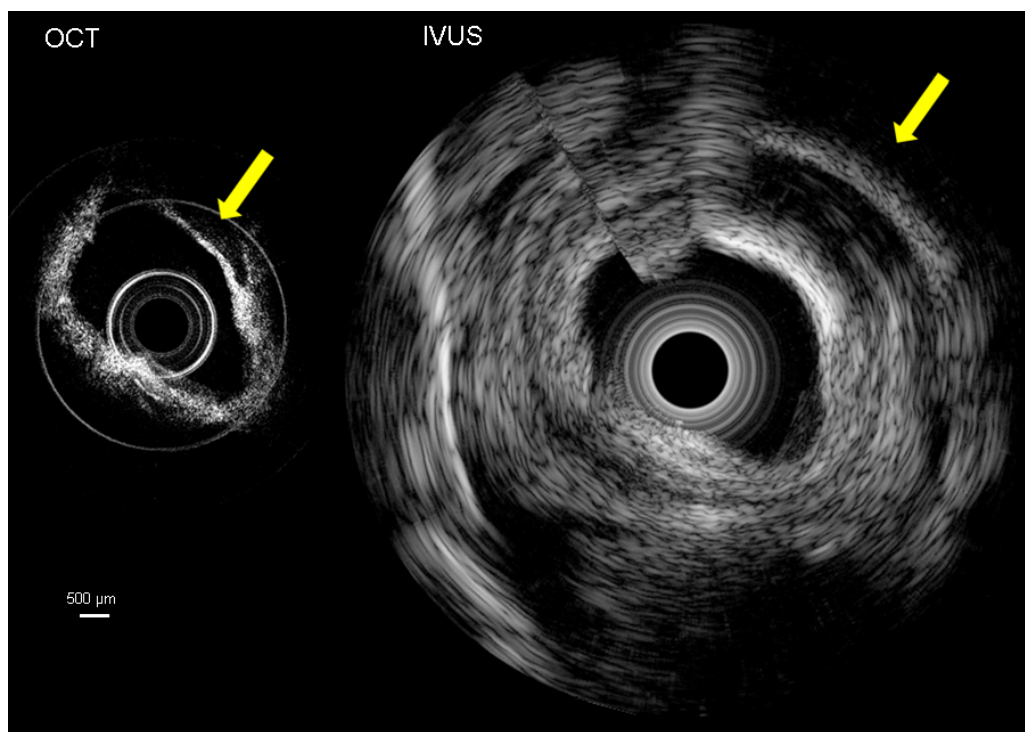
OCT and ultrasound images of human aorta.
